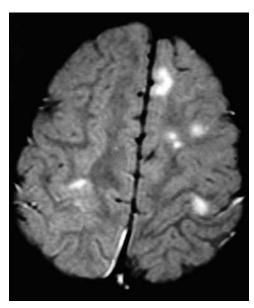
Tuberous sclerosis. MRI demonstrates multiple cortical tubers that appear as areas of increased signal intensity in this T₂-weighted image. The signal abnormalities arise predominantly within the white matter subjacent to the tuber. (*Courtesy Division of Neuroradiology, University Health Center of Pittsburgh, Pittsburgh, Pa.*)
